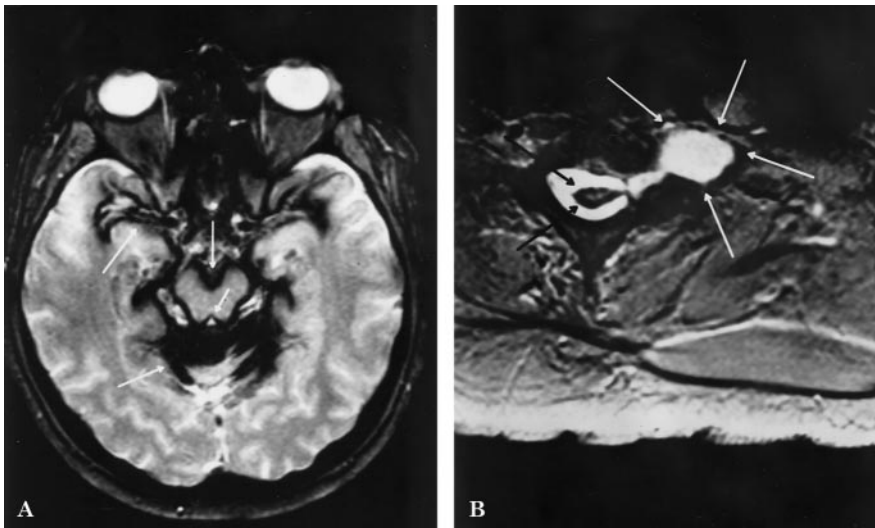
Gradient echo, T2-weighted scans demonstrating a rim of hypointensity on the surface of superior vermis, brainstem and Sylvian fissures (white arrows) (A). Hypointensity is also seen on the surface of the spinal cord (black arrows), along with a large meningeal diverticulum involving the avulsed left cervical roots (white arrows) (B).
